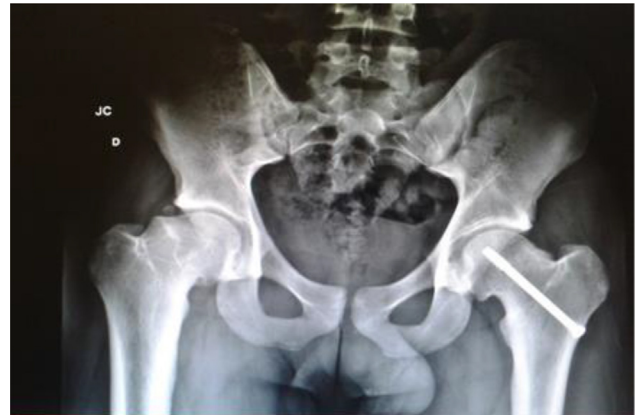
Radiographic image of the pelvis six weeks after arterial repair and screw removal.
